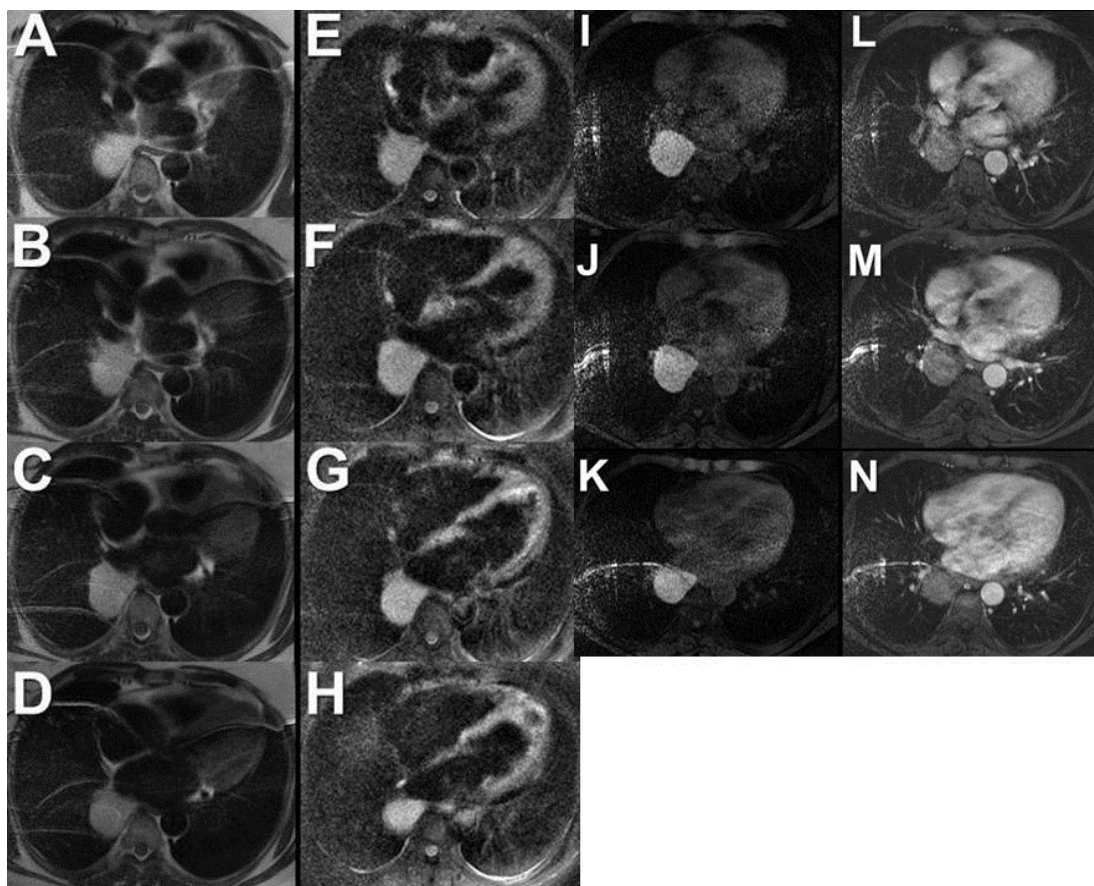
Axial double inversion recovery T1-weighted (A-D), triple inversion recovery (E-H; a fluid-sensitive sequence), axial unenhanced (I-K) and enhanced (L-N) liver acquisition with volume acceleration (LAVA) imaging.
